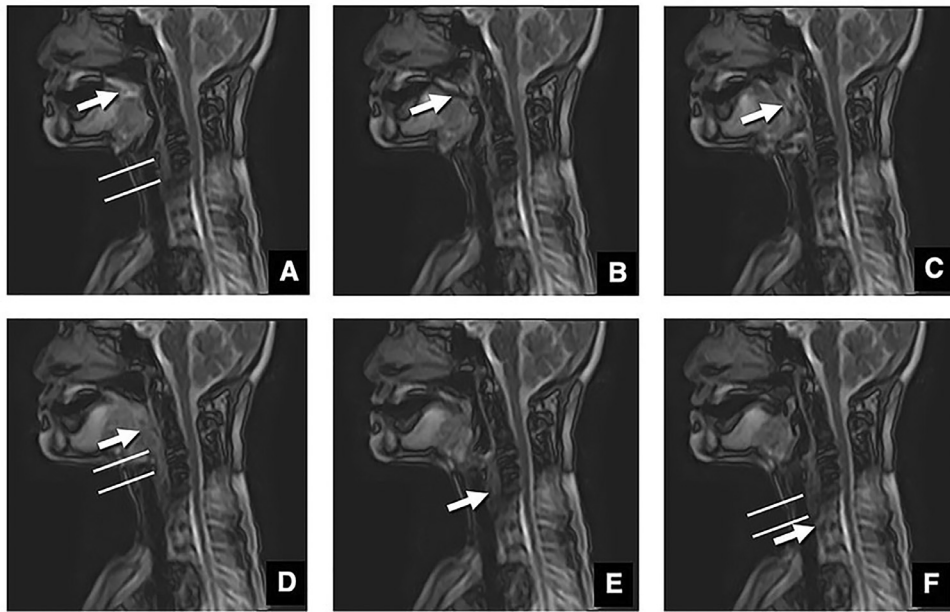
A good-quality swallowing series in the midsagittal plane on cine-magnetic resonance imaging (CMRI) performed after surgery involving subtotal glossectomy, along with tissue flap reconstruction, in a 59-year-old woman with left tongue cancer. A, Oropharyngeal closure (0.79 seconds). B, Velopharyngeal closure (passavant ridge 1) (0.96 seconds). C, Glottal closure (1.11 seconds). D, Esophageal opening (passavant ridge 2) (1.43 seconds). E, Esophageal closure (1.71 seconds). F, Glottal reopening (1.89 seconds). The flow direction to the esophagus can be evaluated. Swallowing was successfully completed with 3 attempts. The mobility of swallowing-related tissues, such as the anterior tongue, base of the tongue, soft palate, floor of the mouth, and pharyngeal posterior wall, tended to not change smoothly, unlike in the normal condition. The ascent and descent of the larynx are highlighted by double lines.
